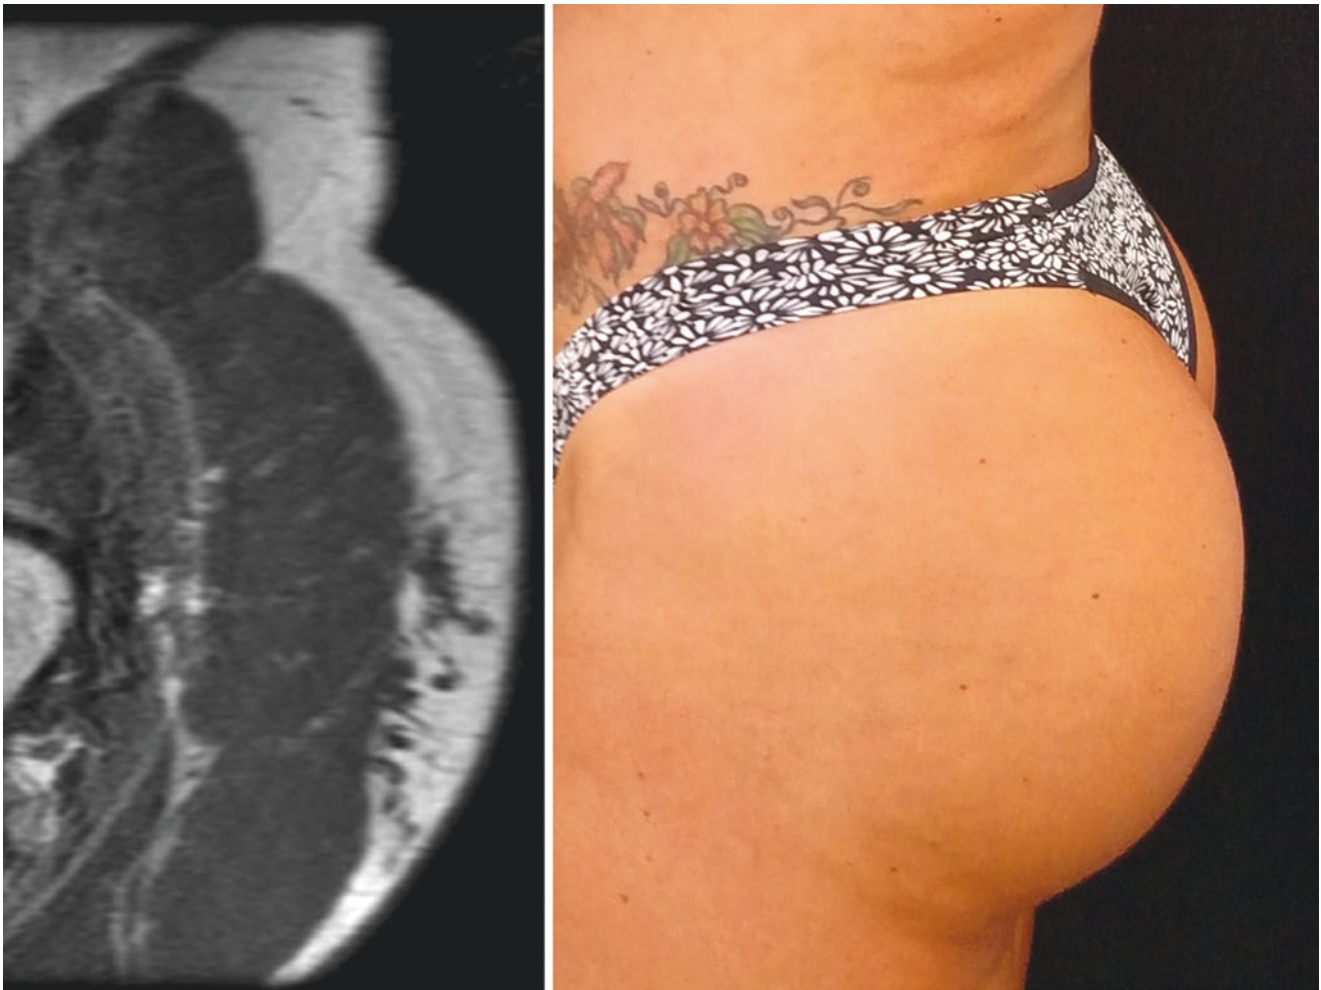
Patient presenting noninflammatory nodule in the left buttock caused by leakage of filler. The nodule is not seen but is palpable and evident on the magnetic resonance image; 2 years after injection of 360 cc of PMMA per buttock
